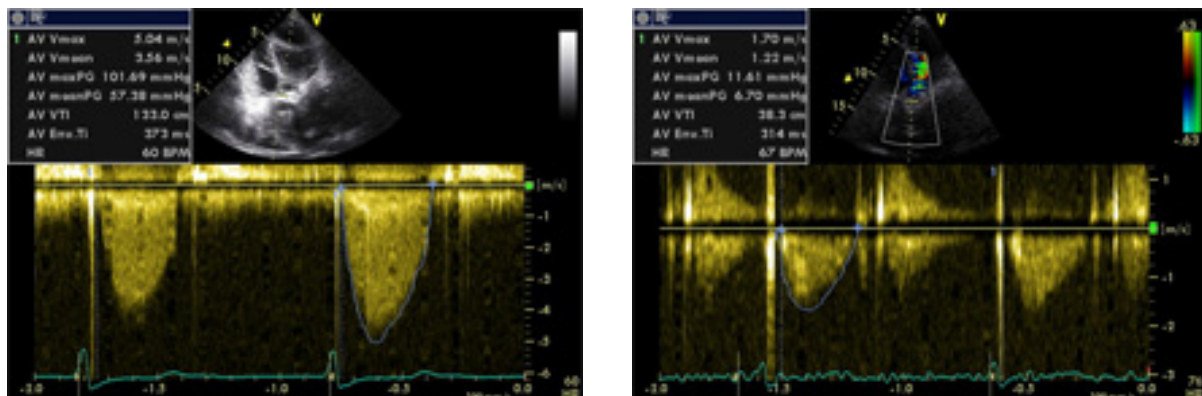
Aortic transvalvular flow (CW Doppler) in an 82 y/o patient with severe aortic stenosis before (left) and one year after (right) PAVR. (89)
